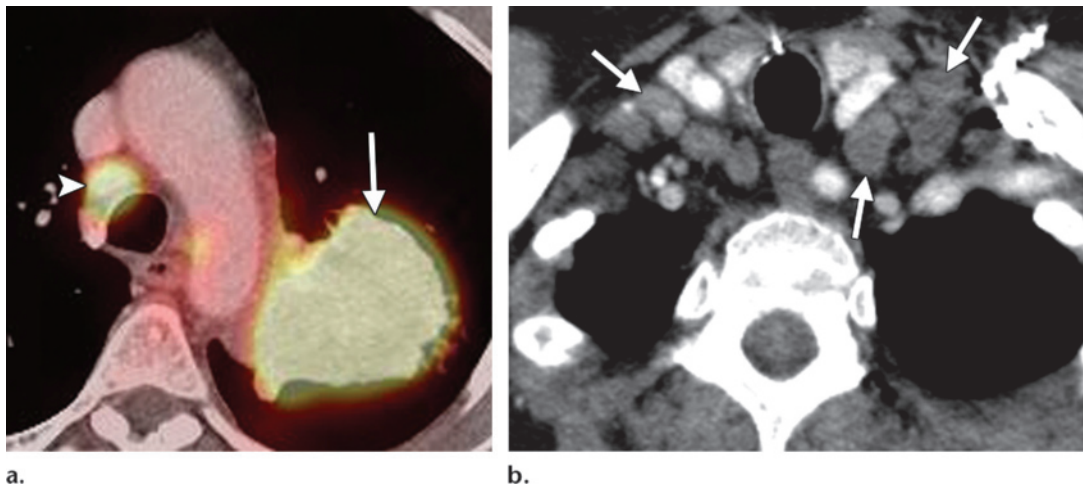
Stage N3 lymph nodes. (a) Axial PET/CT image of the chest shows a primary mass in the left lung (arrow) and a right lower paratracheal lymph node (arrowhead), both of which demonstrate intense radiotracer uptake. Metastatic involvement of the lymph node was confirmed at mediastinoscopic resection. (b) Chest CT scan obtained at the lung apex in a different patient shows enlarged bilateral supraclavicular lymph nodes (arrows). Metastatic involvement was confirmed at excisional biopsy.
